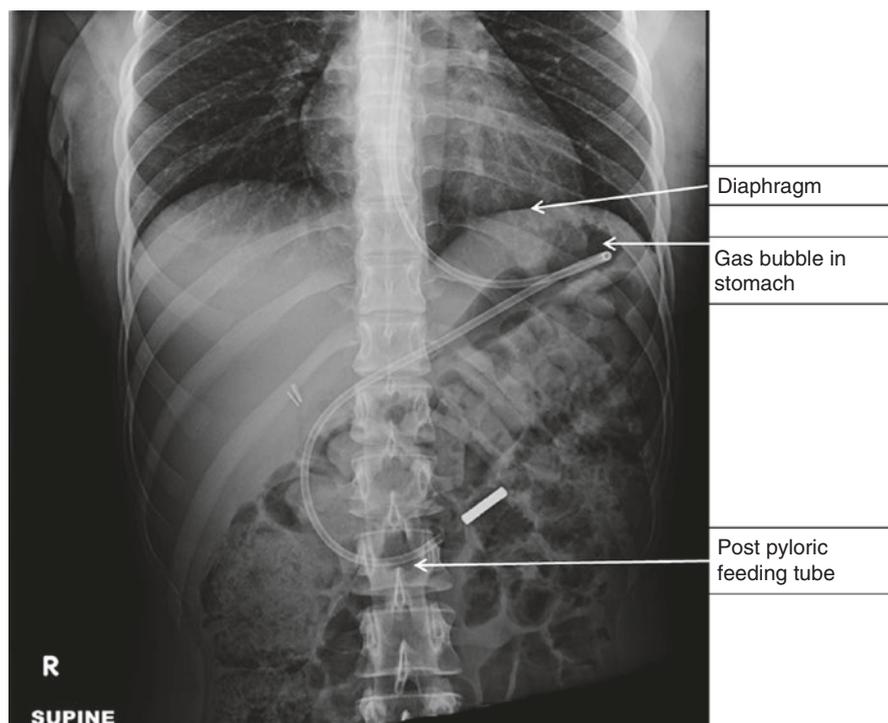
X-ray of an appropriately placed feeding tube
